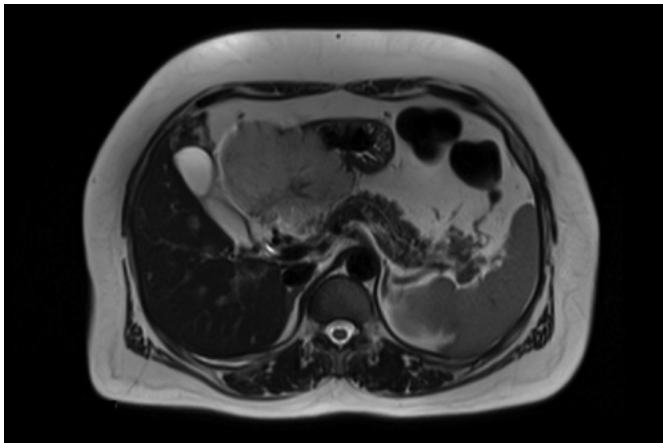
Radiologic assessment of gastric mass at axial T1-weighted MR image
